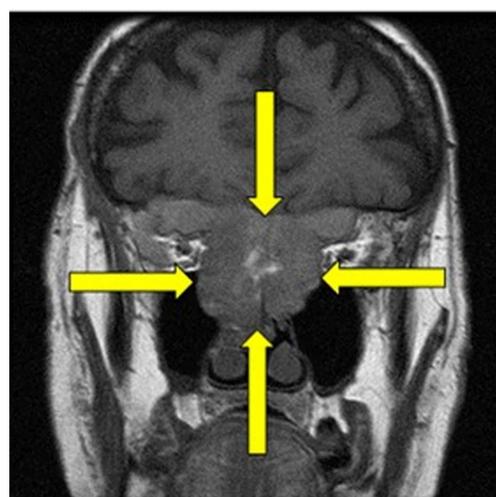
Coronal MRI image showing extensive tumor with skull base invasion.
